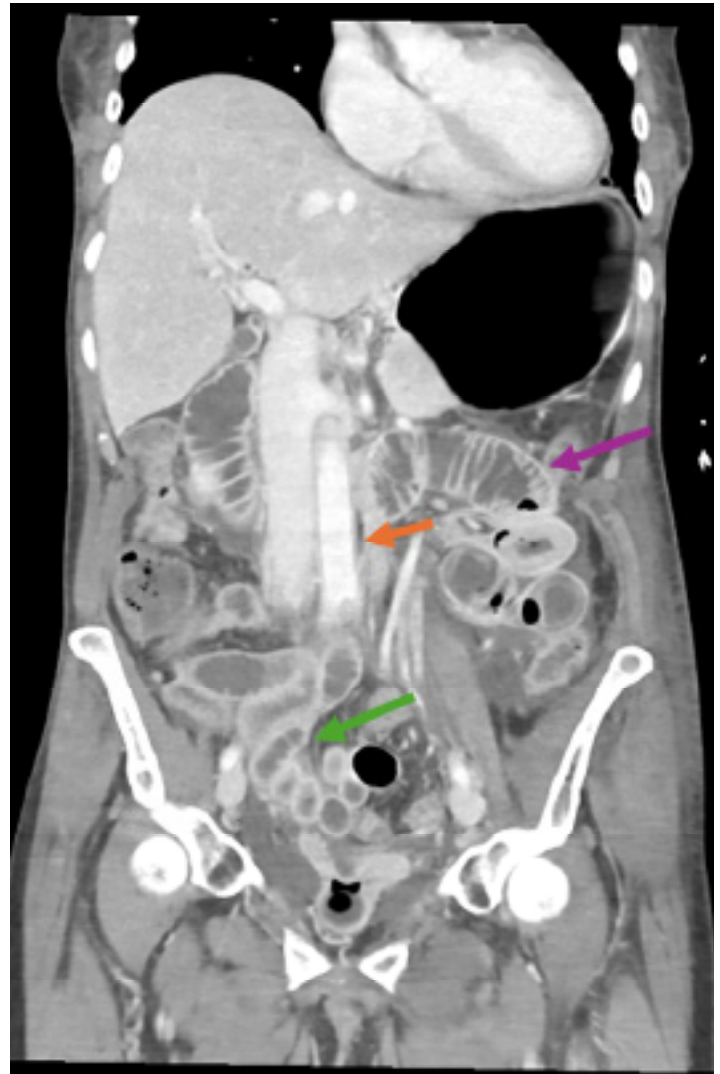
Post contrast computed tomography abdomen and pelvis performed one day after the initial presentation demonstrated the muscular findings; in addition, there was new diffuse thickening of the aorta concerning for aortitis (orange arrow), new proximal small bowel dilatation with areas of thickening (purple arrow) and the distal small bowel hyper-enhancing wall (green arrow) concerning for sequelae of active septic shock.
